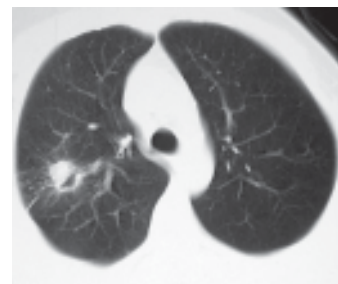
Spiral chest CT shows mucoid impaction (finger-in-glove sign) of dilated bronchi in the right upper lobe.
